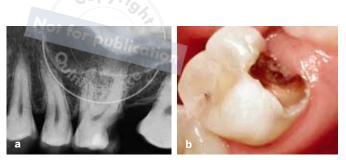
(*a and b*) The assessment of restorability should begin during the examination process because restorability dictates whether endodontic treatment can or should be provided in the presence of pulpal and periapical pathology. (Photo courtesy of Dr Alicia Willette.)
